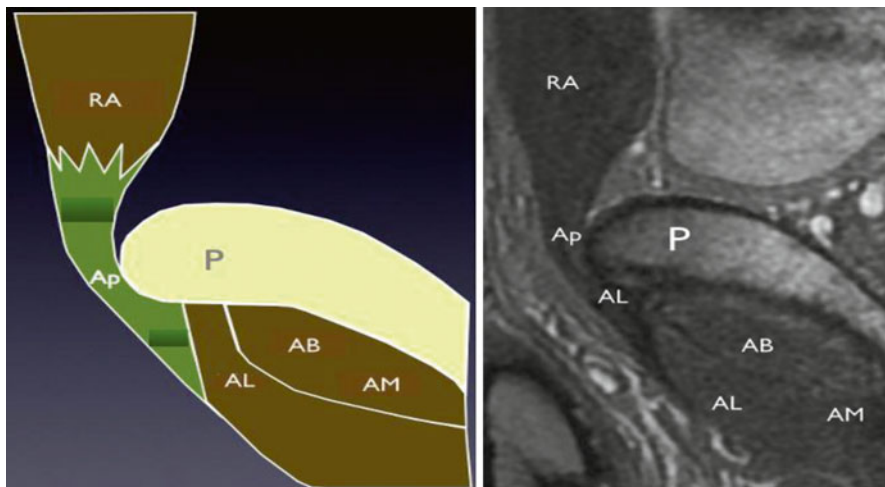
Adductor anatomy on MRI (Pesquer Collection)
